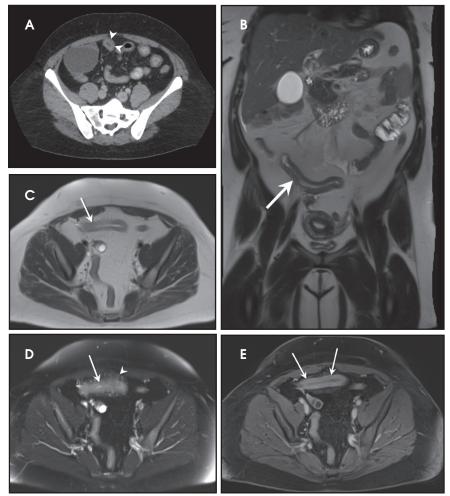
33-year-old woman presenting with acute lower abdominal pain and bloody diarrhea due to active chronic Crohn's disease. Abdominal and pelvic axial CT (A) demonstrates mural thickening in a small-bowel loop in right lower quadrant (A, arrowheads). We were unable to differentiate between inflammation and fibrosis in the thickened bowel loop. An MRI was performed for differentiating active disease, and includes coronal (B) and axial single-shot T2W images without (C) and with (D) SPAIR fat-suppression. The MRIs show abnormal high signal involving thickened distal ileal loops (C and D, arrows) and extending into the adjacent mesentery (D, arrowhead). The high T2 signal identified in the thickened bowel wall and surrounding mesentery is a hallmark of active disease; the elevated abnormal T2 signal is most conspicuous on fat-suppressed images (C versus D). Axial delayed-phase postcontrast T1W 3D GRE images (E) show abnormal thickening and contrast uptake within the thickened wall of the distal ileum (E, arrow), findings in keeping with active on chronic Crohn's disease and corresponding to the surgical pathology findings of inflammation and submucosal fibrosis in this case.
